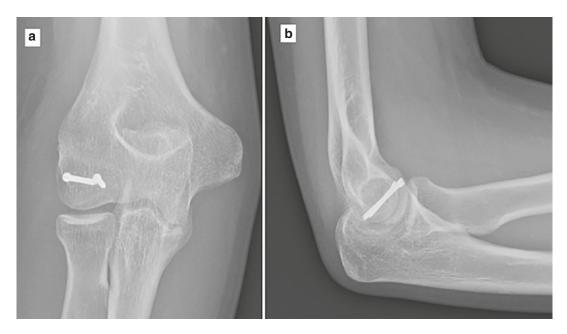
(a) AP and (b) Lateral radiograph taken from clinic follow-up one month following surgery demonstrating maintenance of the position of the capitellum and no change to the position of the headless compression screws
